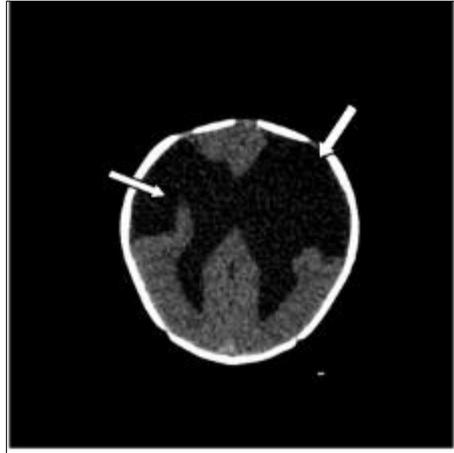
Bilateral schizencephaly with open cleft; axial CT sections at 8 days of age showing biventricular hydrocephalus communicating bilaterally with the subarachnoid spaces via a cleft (arrows)
